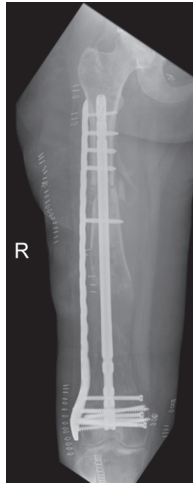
Post-operative A/P femur radiograph after successful docking site procedure and exchange of the Precice nail with a standard retrograde femoral intramedullary nail
